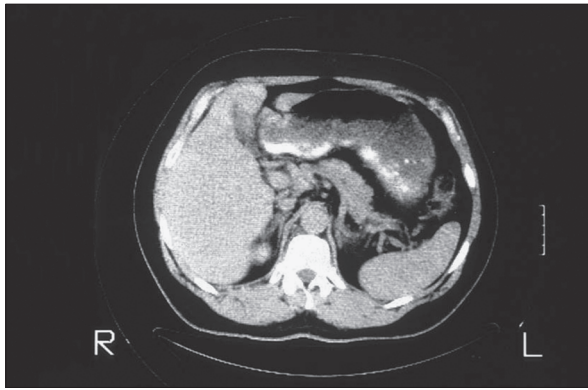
CT scan showing bilateral adrenal gland hyperplasia.
